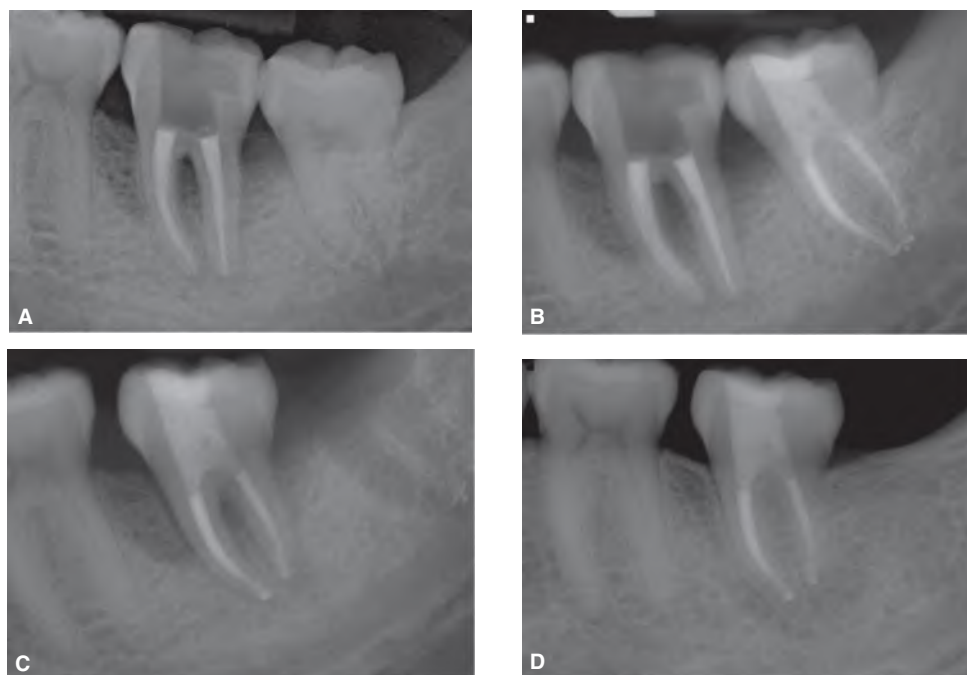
A. Preoperative radiograph of a second mandibular molar shows presence of symptomatic apical periodontitis and severe bone loss. B. Postoperative radiograph of the tooth after root canal treatment of the third molar. C. After auto transplantation of the third molar into the socket of second molar. D. A radiograph taken 46 months later shows complete healing of the periapical tissues around this tooth.
